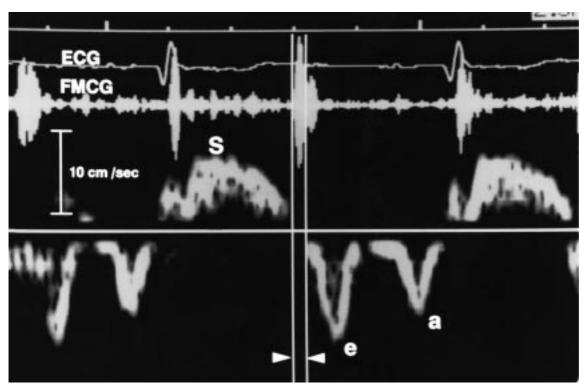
Normal pulsed wave Doppler tissue imaging pattern. The sample volume is located in the left ventricular inferior wall. S=systolic wave; e=early diastolic velocity of relaxation; a=late diastolic velocity of relaxation. The local isovolumetric relaxation time was measured as the interval from the second heart sound to the onset of the early diastolic velocity of relaxation (arrows).
